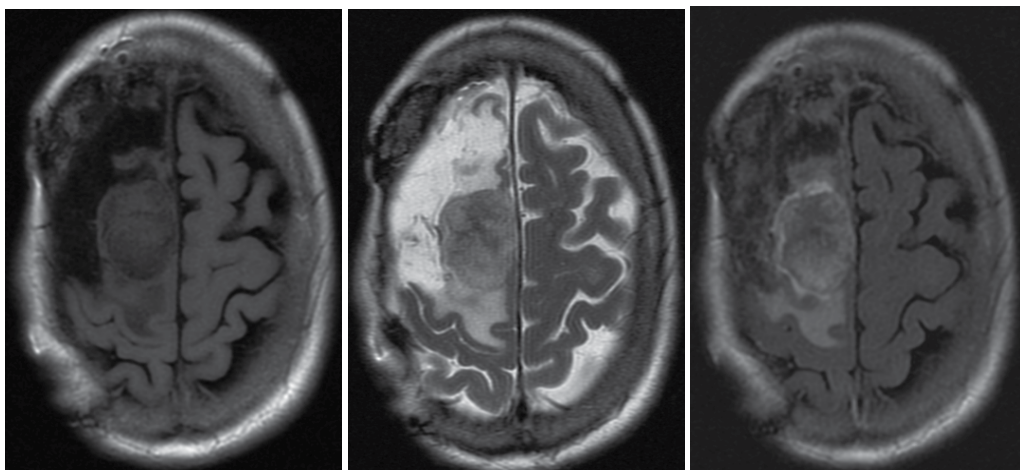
Axial MRI of a right parasagittal anaplastic meningioma in a 72-year-old woman. Image on the left is FLAIR T1, in the middle is T2 and on the right is T2 FLAIR with gadolinium.
